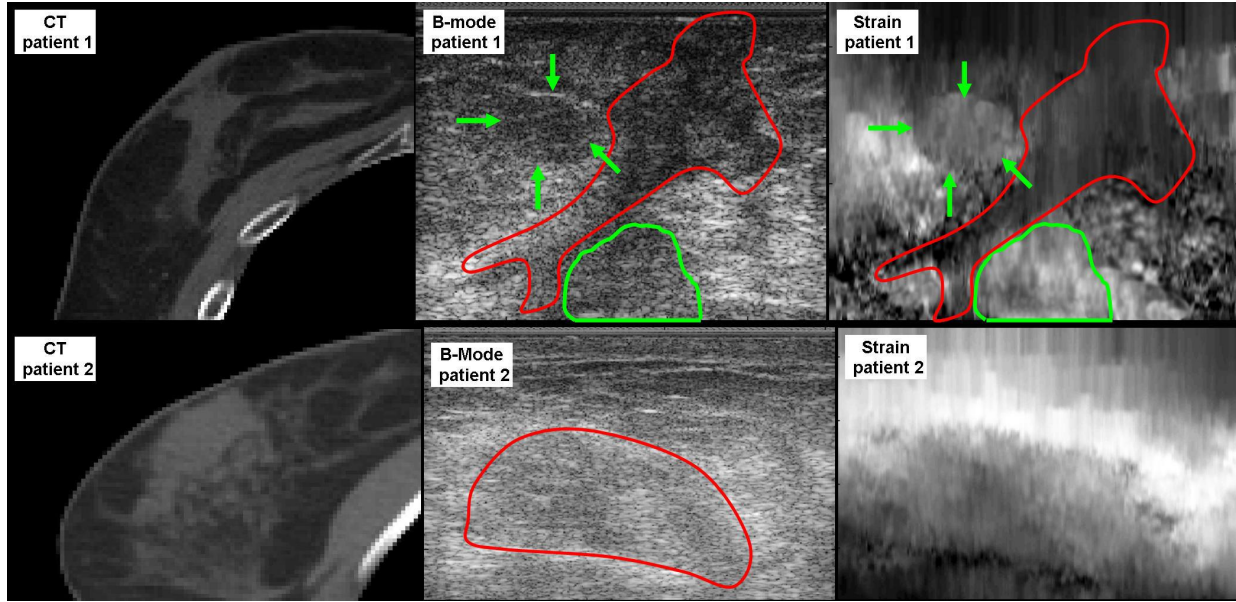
CT, B-mode and strain images from the first two patients.
